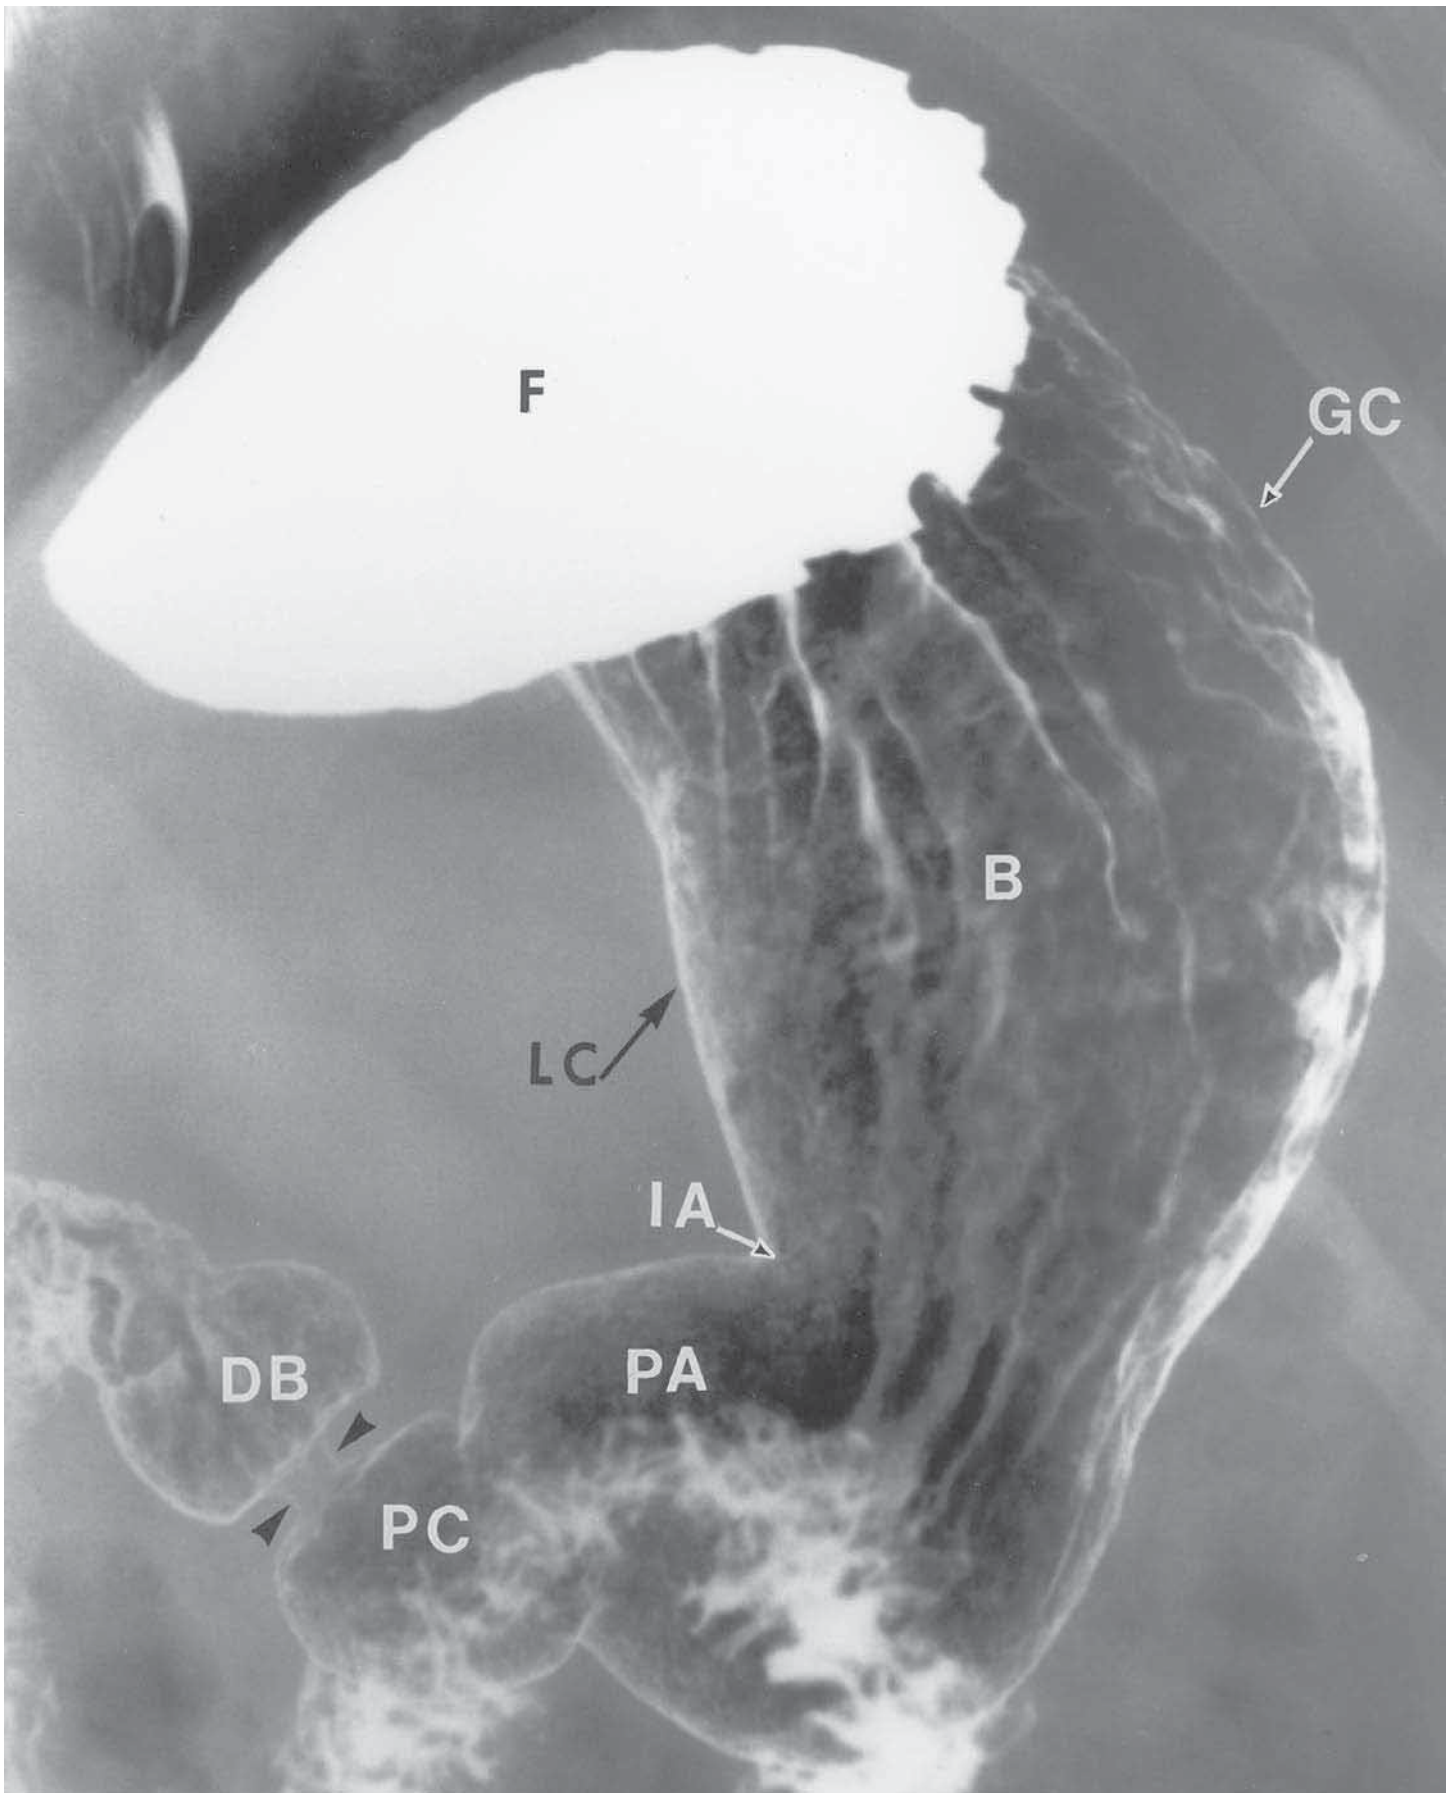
X-Ray of the J-Shaped Stomach Showing Its Different Parts
